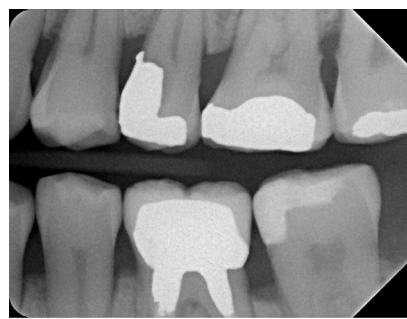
January 2008 - Left bitewing showing intact mesio occlusal restoration in the LL7
